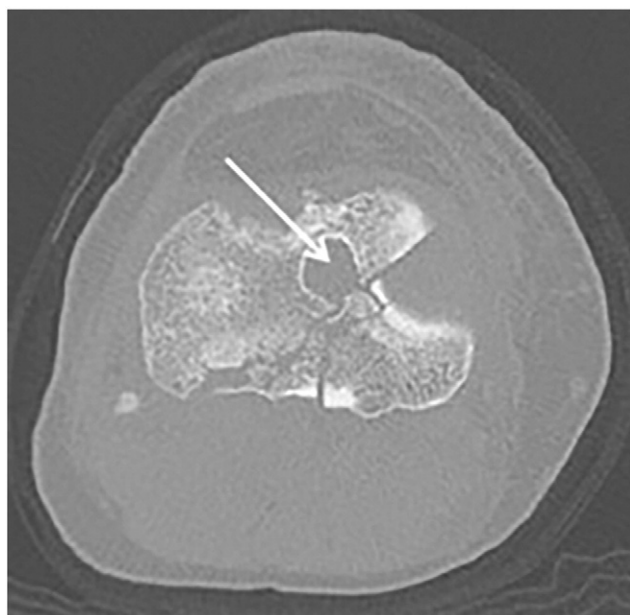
Transverse computed tomography scan revealing a fracture through the tibial tunnel (indicated by arrow) and tunnel widening, from 10 mm at the time of reconstruction to 13.5 mm at the time of plateau fracture.*
